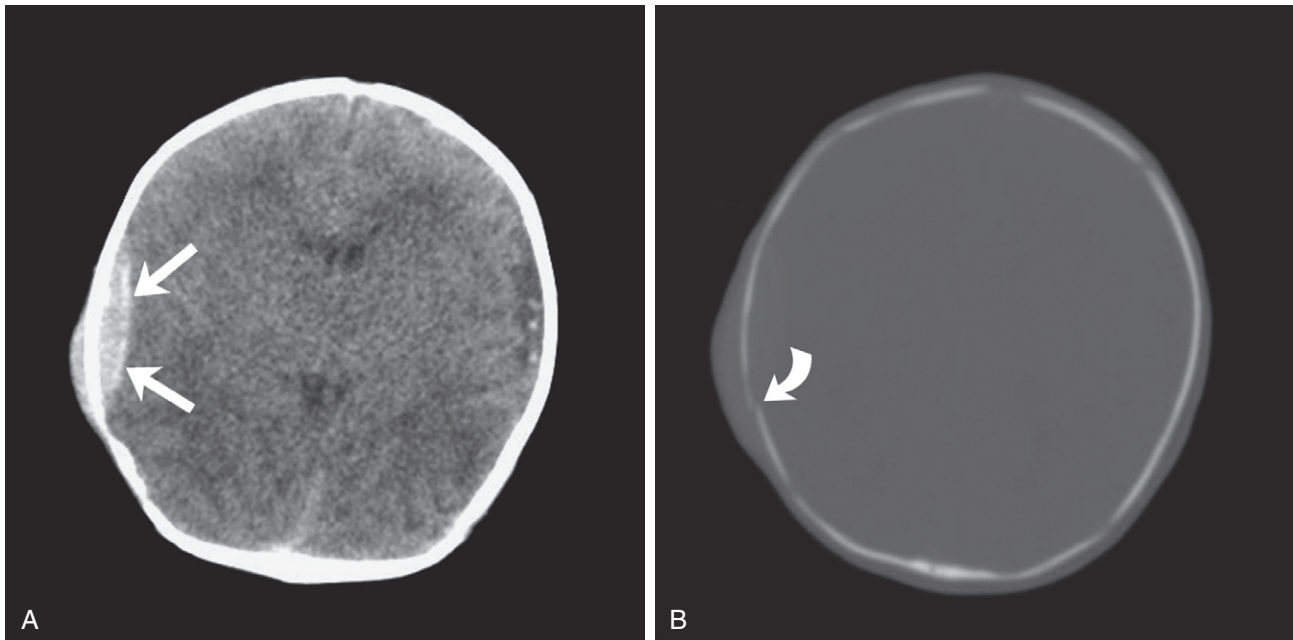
Epidural hematoma with skull fracture. A CT scan in brain (A) and bone (B) windows shows the typical lentiform configuration of right-sided epidural hematoma (arrows). The bone window reveals an associated fracture (curved arrow).
